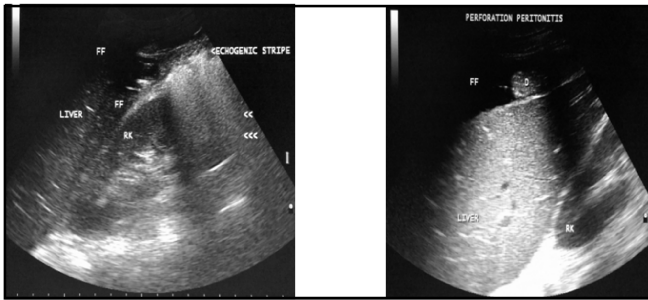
Sonographic Appearance of Perforation. The Free Intra-peritoneal Air Appears as Diffusely Echogenic Stripe with Dirty Posterior Shadowing.
